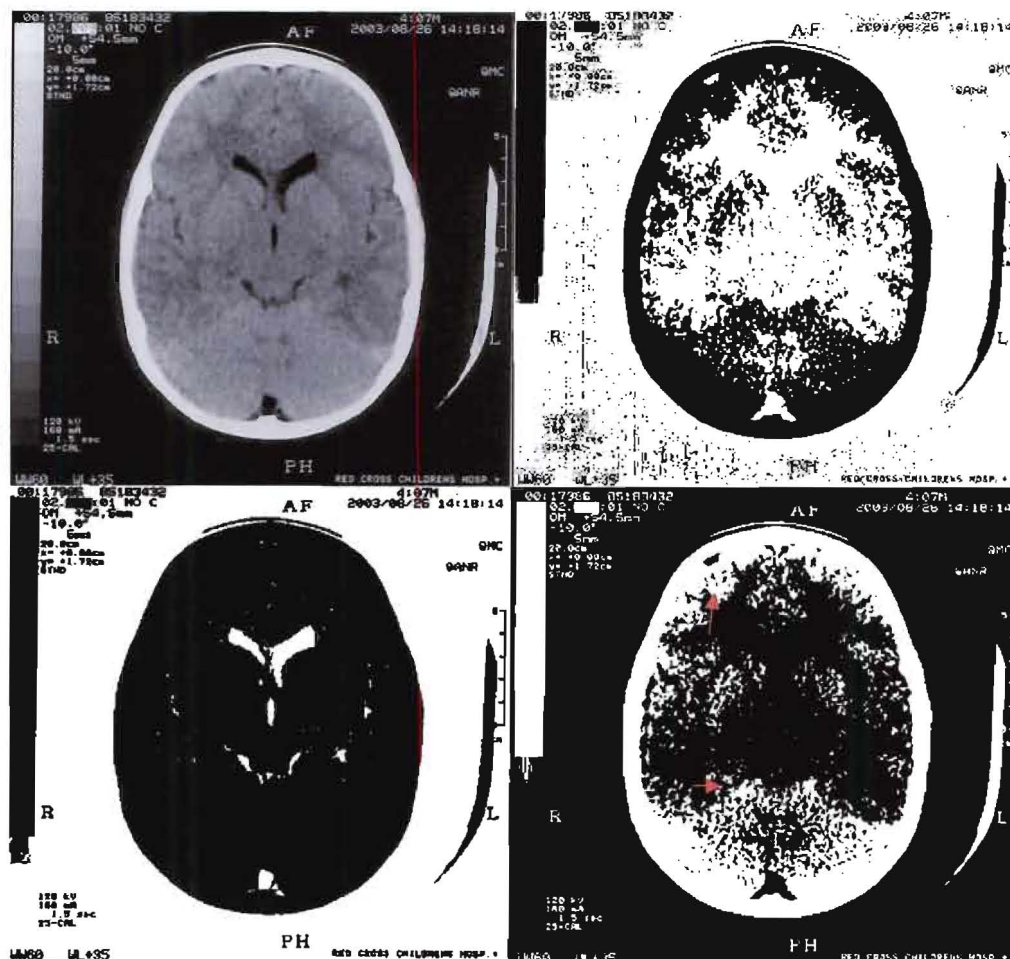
Images showing the results of applying k-means clustering to a normal brain CT scan
